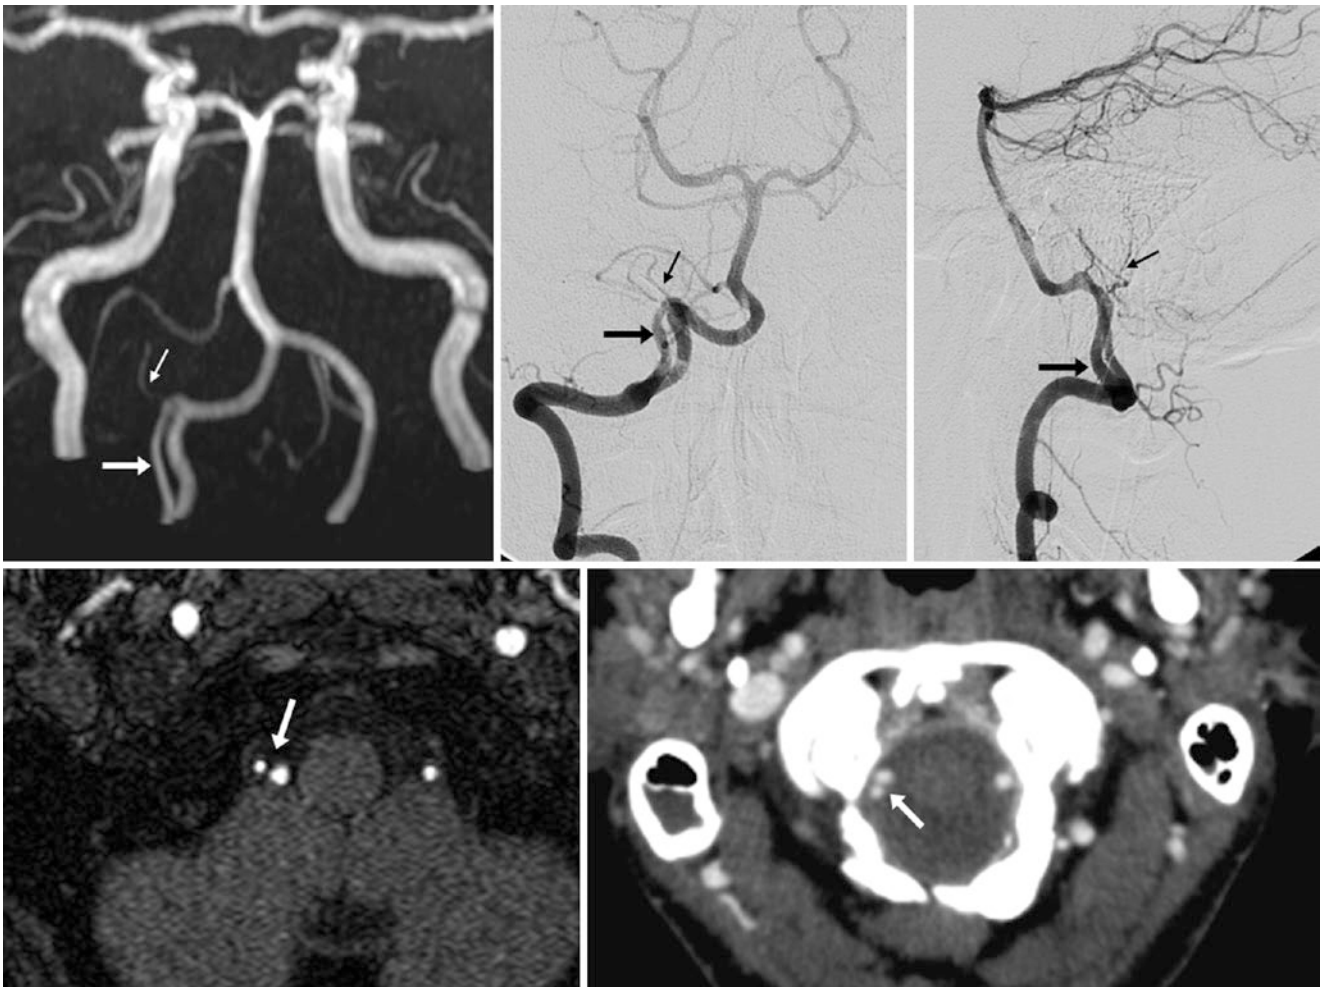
40-year-old with a large VA fenestration (*large arrows*) near the craniocervical junction on a 3DTOF MRA AP view (*top left*) and on a source image (*bottom left*). Catheter DSA AP and lateral views (*top middle and top right*) and source CTA images (*bottom right*) also depict the fenestration. The right posterior inferior cerebellar artery (PICA) (*tiny arrows*) arises from the superior aspect
